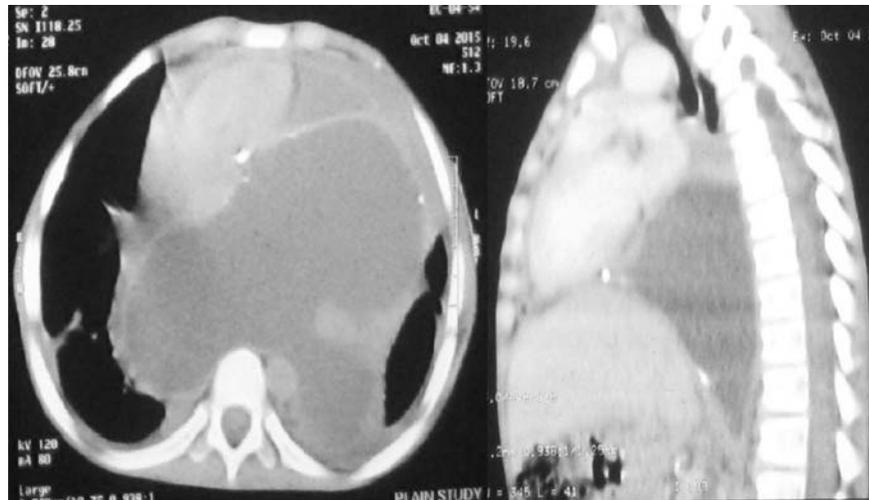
Contrast-enhanced computed tomograph of thorax shows large encysted mediastinum lesion with tri-lobate shape, thick enhancing walls and lobulated outlines in the posterior mediastinum. The heart is pushed anteriorly with mild pericardial effusion.
